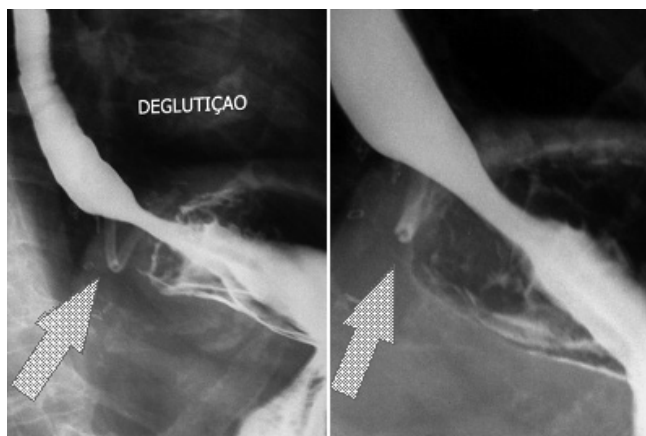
Radiographies showing the proper positioning of the mesh and the esophagogastric junction
